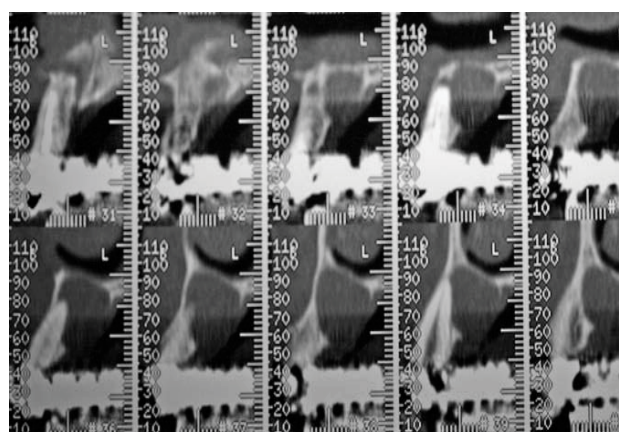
Transverse view of the maxillary region. CT image.
